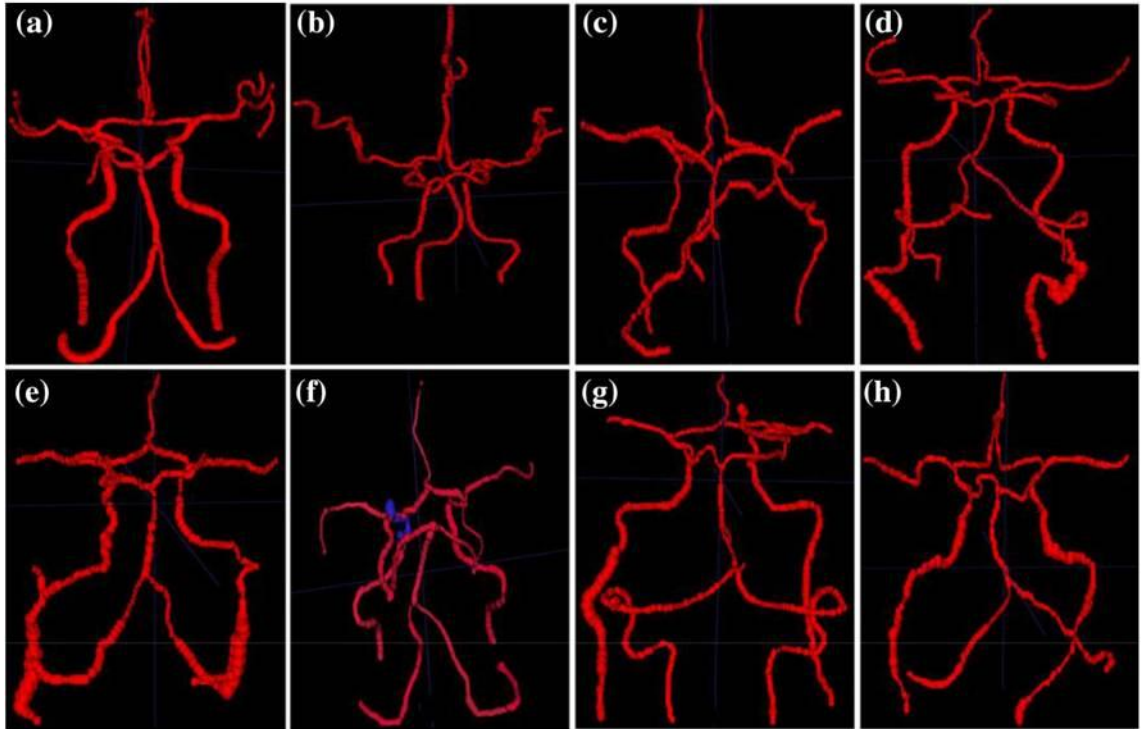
a–h Segmentation of circle of Willis part from 8 different CTA images. Image id—a 2005, b 1016, c 2001, d 2008, e 2009, f 3029, *blue coloured* portion is aneurysm g 3032, h 3036
